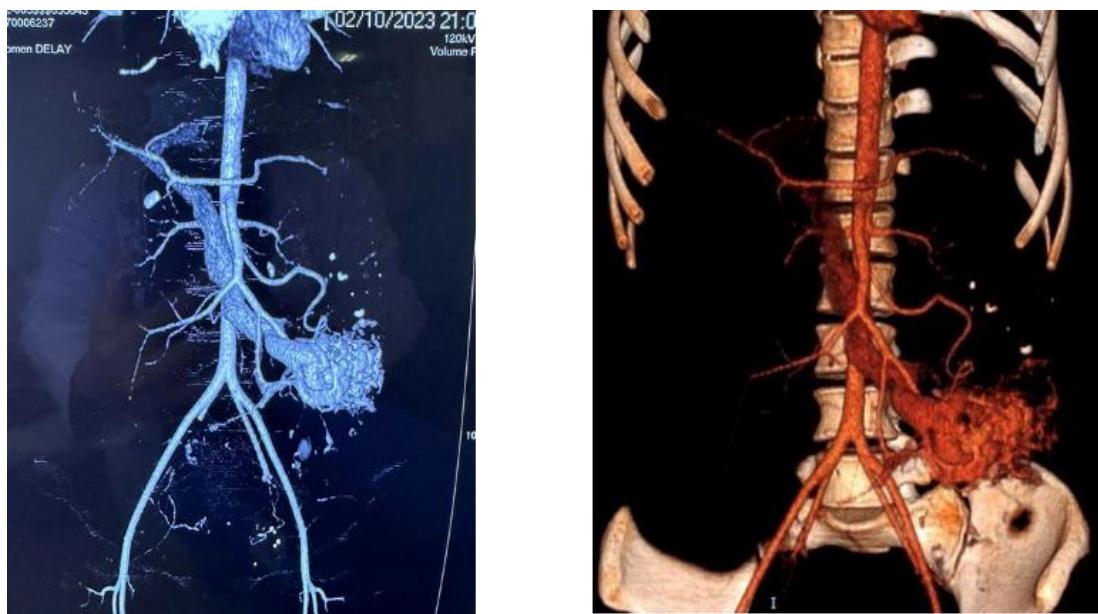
Reconstructed CT Angiography of the Aortoiliac arteries
